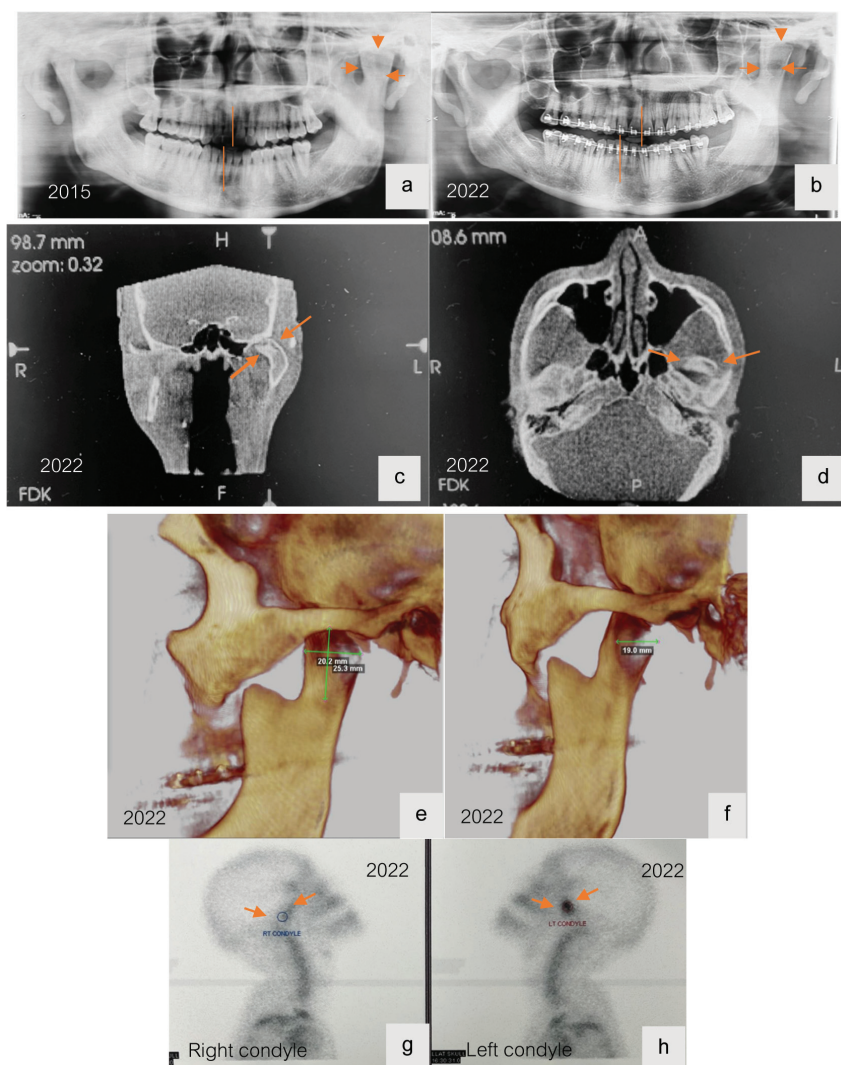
The preoperative panoramic radiograph showed a well-circumscribed radiopaque lesion with a thin corticated rim at the left condyle (b). The lesion became larger, and the lower dental midlines progressively shifted to the right compared with the previous radiograph (a, b). Large FOV cone beam CT coronal and axial views revealed medial expansion of the lesion with a thin cortical rim at the left condyle of the mandible (c, d). The size of the affected condyle was ~20.2 mm, 25.3 mm, and 19.0 mm in sagittal, vertical, and medio-lateral dimension, respectively (e, f). The latest bone scintigraphy performed in 2022 showed active growth of the left condyle (h).
